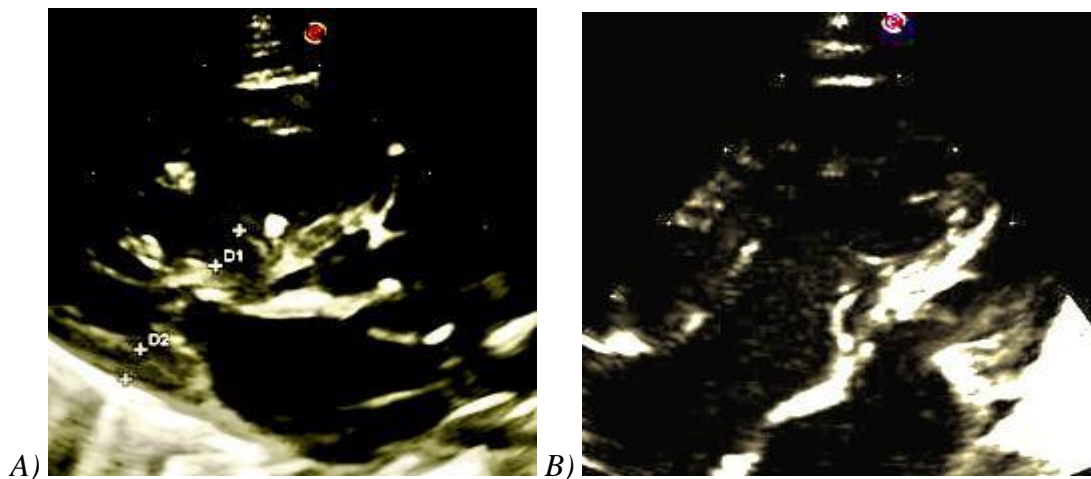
A) In parasternal LX view a small left ventricular cavity size with a moderately dilated right ventricle was ascertained. B) Similar findings were present in apical 4CH view alongwith normal biventricular systolic function.
